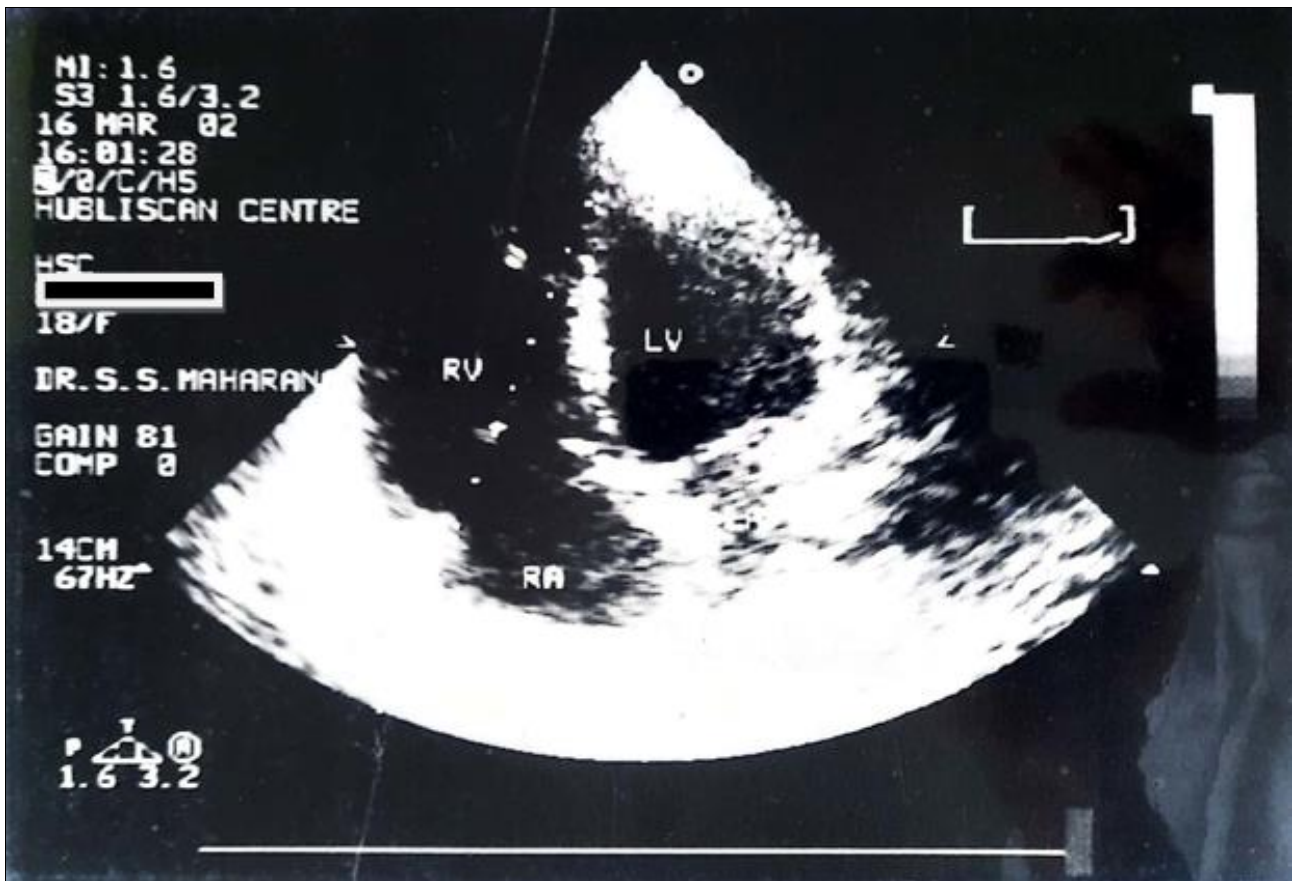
Echocardiogram of pulmonary hypertension of cor pulmonale case before treatment
